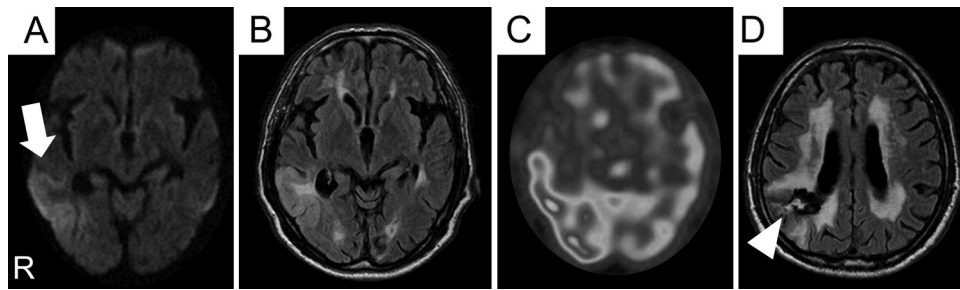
MRI and SPECT on admission. MRI shows slight hyperintensity in the right temporo-occipital lobe on DWI (A, arrow) and FLAIR (B). SPECT using intravenous injection of ^{99m}Tc -PAO shows increased ^{99m}Tc -PAO uptake in the lesion (C). FLAIR shows old ICH in the right parieto-occipital lobe (D, arrowhead).
